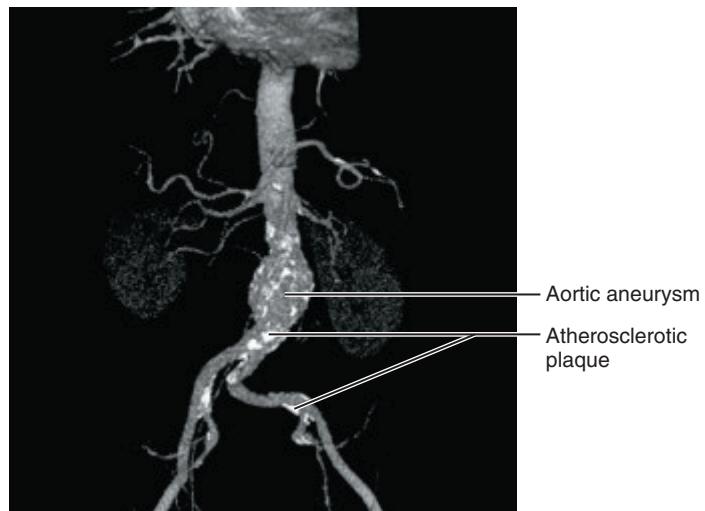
Sixty-four-slice CT angiogram of an abdominal aortic aneurysm.
